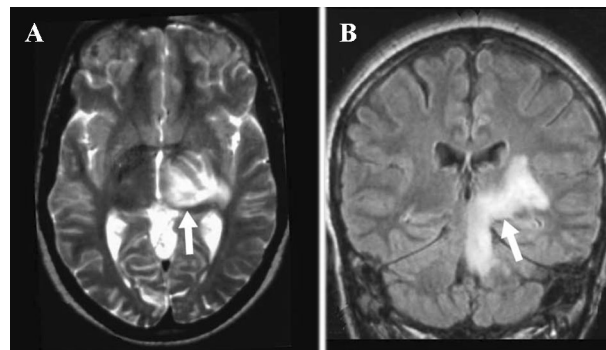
Axial T2-weighted (A) and coronal FLAIR (B) imaging showing a left-sided NBD brainstem lesion extending into the diencephalon and the deep grey matter
